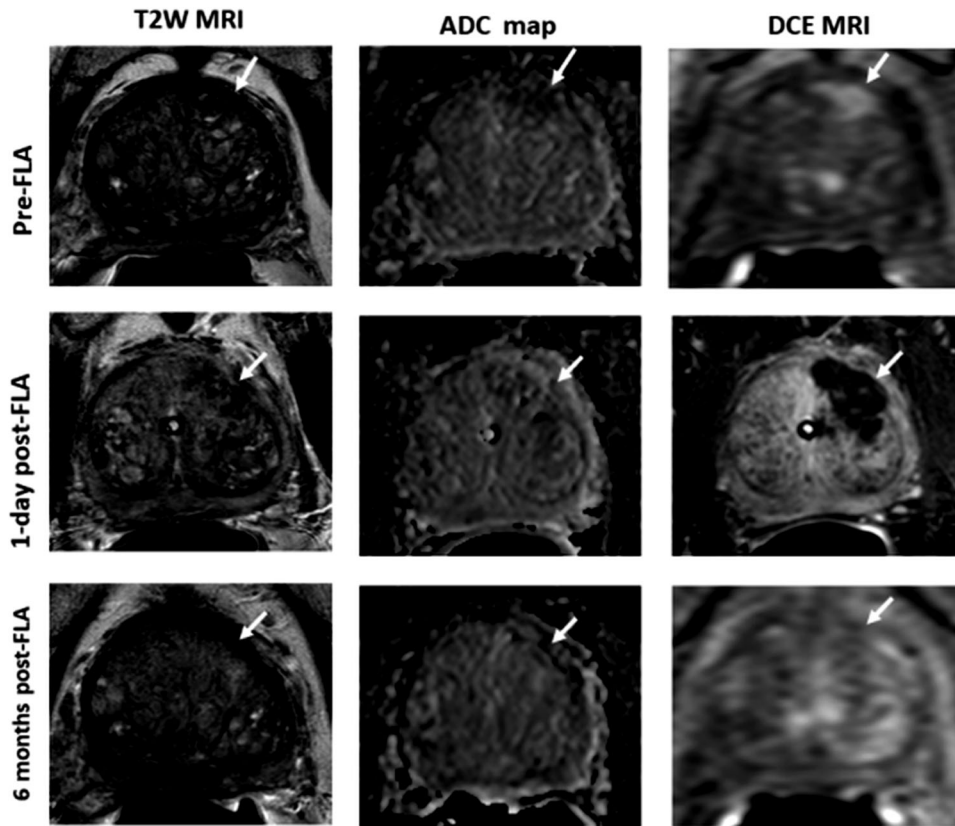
Multiparametric MRI images showing a Gleason Grade 2 left mid-anterior transition zone lesion treated with focal laser ablation (FLA) without tumor recurrence. From top to bottom: MRI before FLA, 1-day post-FLA MRI with early findings of necrosis and edema, and 6 months post-FLA MRI without evidence of residual/recurrent disease confirmed with fusion targeted guided biopsy.
